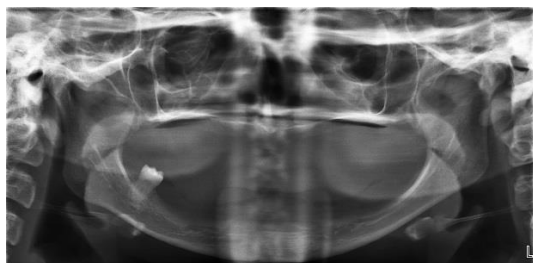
Panoramic radiographic image showing completely edentulous maxilla and a molar in right side of the mandible.
